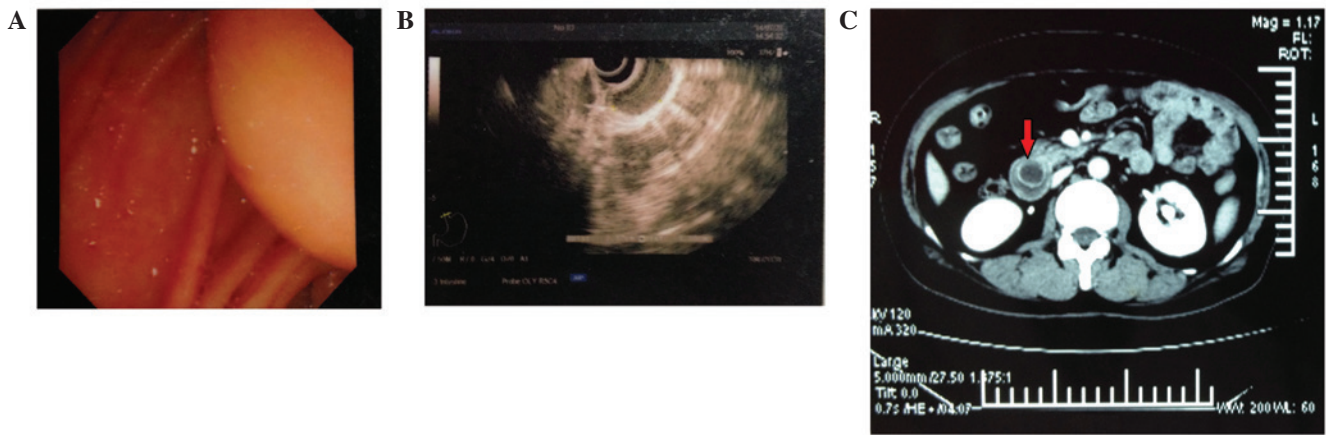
(A) Gastroduodenoscopic examination revealed the presence of a 2.37x1.20-cm half-globular, submucosal mass located in the descending region of the duodenum. (B) Endoscopic ultrasound revealed that a submucosal, low-echo conglomeration, which originated from the muscle layer, was located in the wall of the duodenum near the duodenum bulb. (C) An axial portal arterial-phase computed tomography scan revealed the presence of a spherical low-density mass (arrow), which possessed a thick wall abutting the duodenal bulb, and the presence of a cyst in right lobe of the liver.
